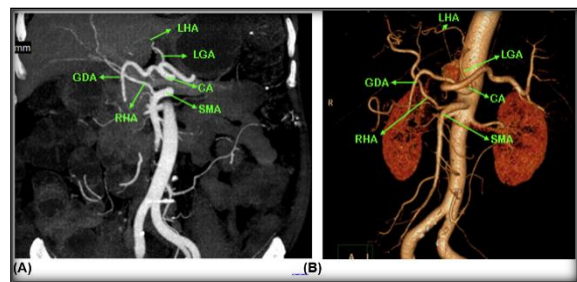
MIP CT angiogram of abdominal aorta showing coronal view (A) and 3D reconstruction (B) of Type IV with replaced RHA arising from the SMA along with replaced LHA from the LGA.
